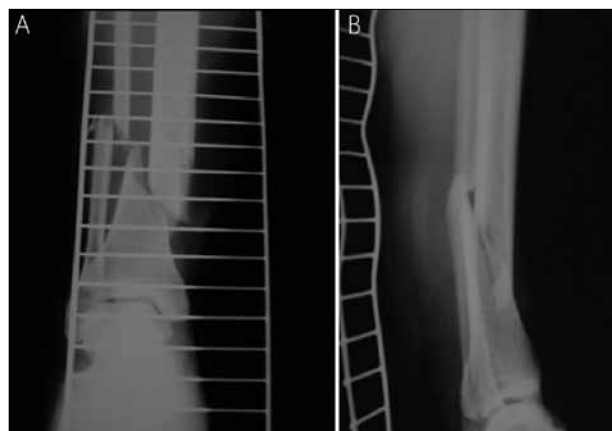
The antero-posterior (A) and lateral (B) X-rays demonstrate spiral fractures in the distal tibial and fibular shaft with dislocation of fragments
